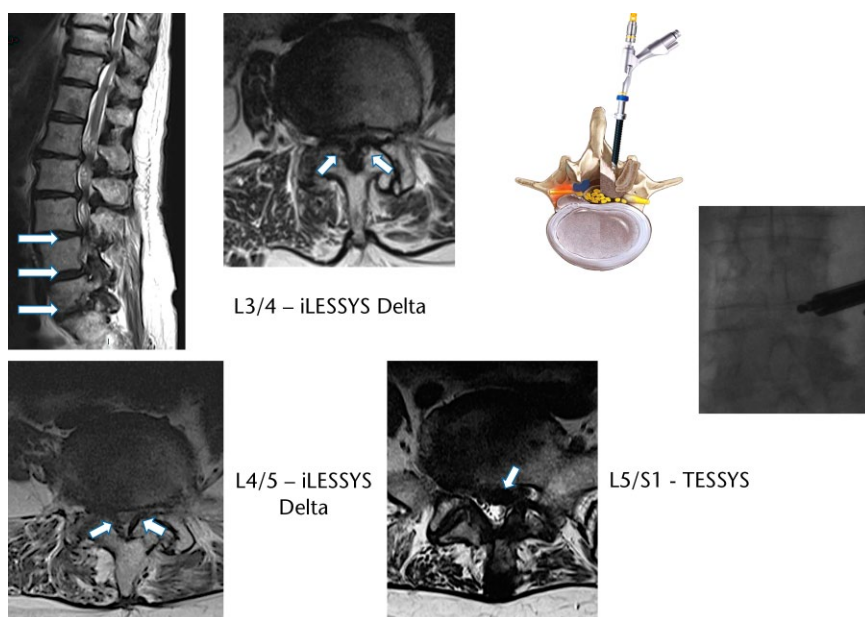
Severe central canal narrowing from L1 to S1. Axial T2 images at L3/4, L4/5 and L5/S1. Anteroposterior image intensifier radiograph showing cannula position (iLESSYS Delta, Inter Lamina Endoscopic Surgical System; TESSYS, Transforminal Endoscopic Surgical System).
